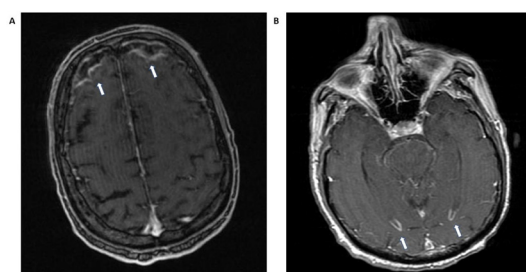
MRI head. (A) Fast spoiled gradient recalled 3D sequence with contrast showing bilateral frontal subdural fluid collections measuring up to 1.1 cm on the left and 1 cm on the right (arrows). (B) Axial T1 weighted with contrast showing signal abnormalities within the occipital horns of both lateral ventricles consistent with ventriculitis (arrows).
